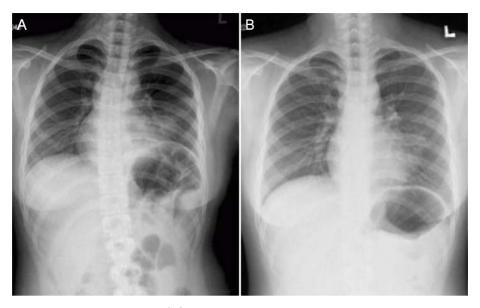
Current Chest X-ray (A) showed the prominent infiltration along with left cardiac border, which was similar to that of previous 3 months (B).
